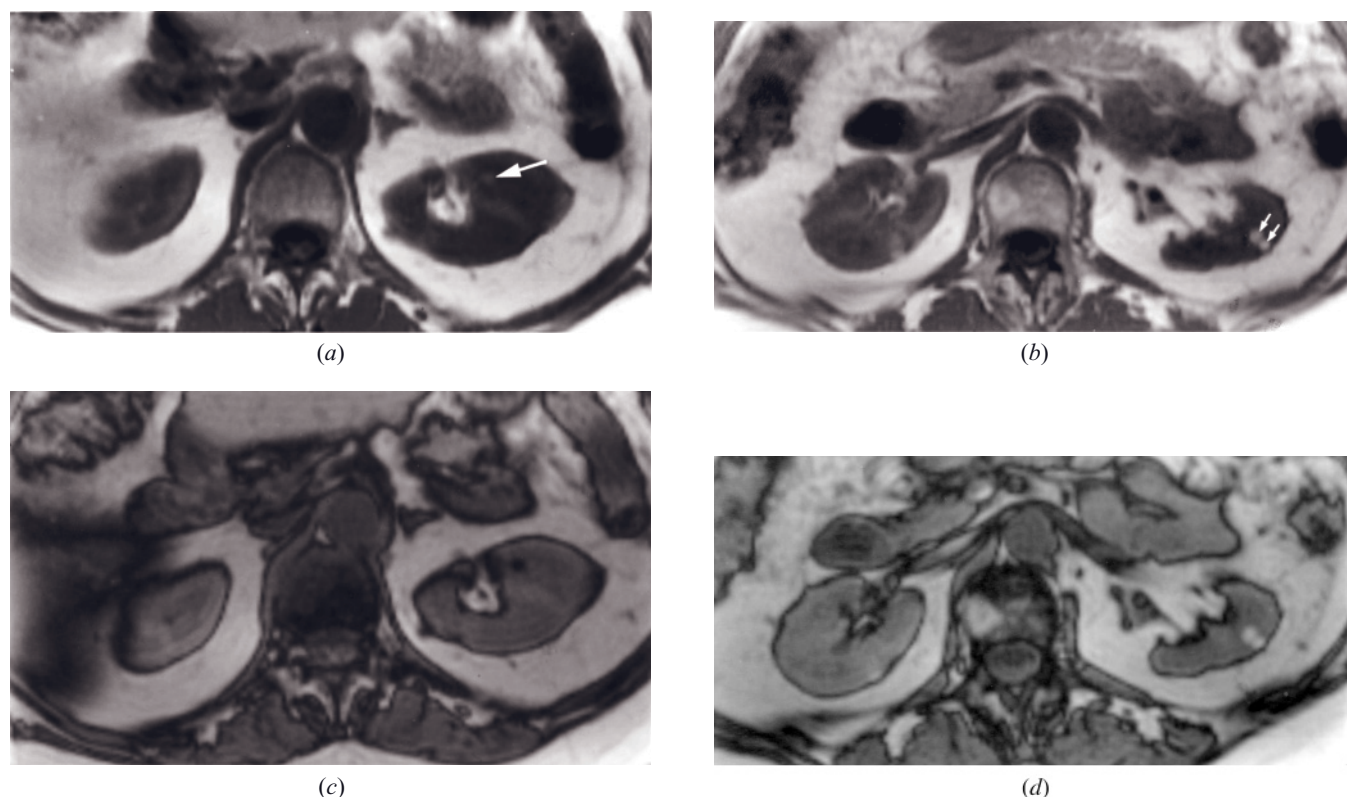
Angiomyolipoma and hemorrhagic cyst. T1-weighted precontrast in-phase (*a, b*) and out-of-phase (*c, d*) SGE images. The angiomyolipoma (arrow, *a*) is high signal on in-phase and signal void on out-of-phase (*c*) images. The hemorrhagic cysts (arrows, *b*) are high signal on in-phase (*b*) and out-of-phase (*d*) images.
